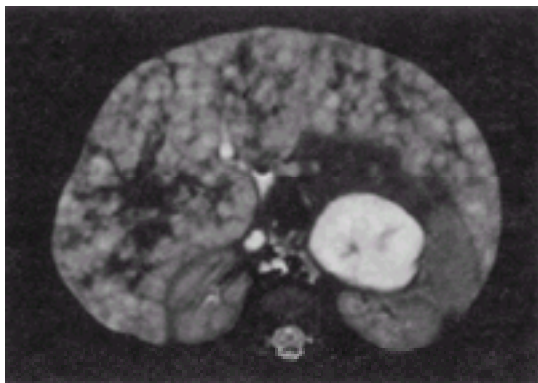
MRI scan of a 3-month-old infant who presented with a large upper abdominal mass demonstrates extensive involvement of the liver with the tumor shown to be a neuroblastoma by biopsy. A follow-up scan 8 months later demonstrated complete resolution of the tumor.
